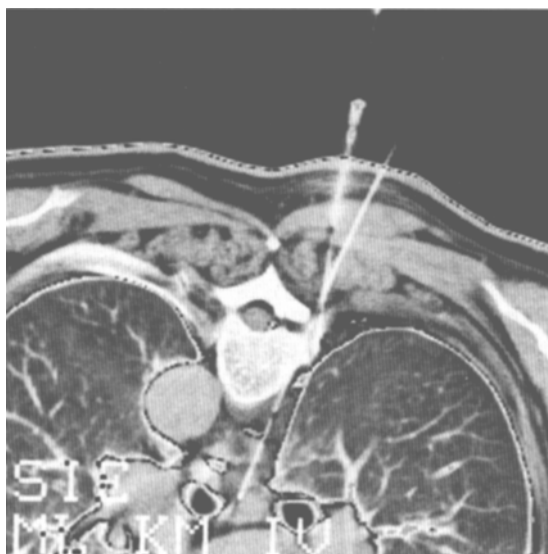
Biopsy inside the mediastinum with CT guidance. The microinstrument was guided carefully and precise into the tumor without damaging the segmental nerve, lung, esophagus or arteries (high risk areas [HiRA]). The space between lung and spine normally has a diameter of 1 to 2 mm. With 2 cannulas this space can be dilated with local anesthesia and saline solution.
